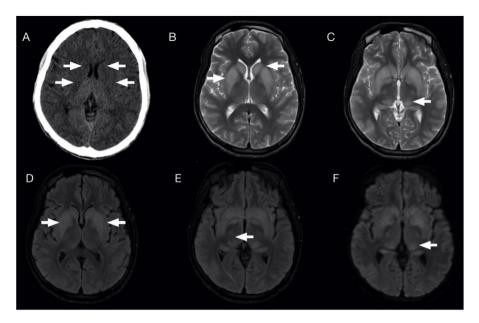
Thirty-three-year-old male, with hypernatraemic dehydration and impaired consciousness, admitted upon disembarking from small boat. Non-contrast brain CT shows areas of hypodensity and dedifferentiation which affect both the caudate and lentiform nuclei bilaterally and symmetrically (white arrows) (A). The MRI performed later confirmed the existence of areas of signal hyperintensity in caudate and lentiform nuclei in the T2-weighted (B and C) and FLAIR (D and E) sequences as well as in the posterior margins of both thalami (C and E), with hyperintense signal in diffusion-weighted images (F) in which no restriction was seen on the ADC map nor enhancement after contrast administration.
